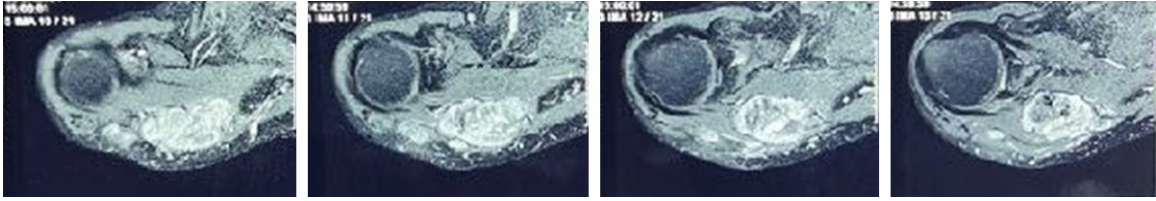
T2-weighted axial section MRI of shoulder showing large, focal well defined heterogeneously enhancing mass in the subcutaneous plane, abutting the spine of scapula, measuring approx. 5.6 × 8.5 × 2.7 cm in antero-posterior, transverse, and superoinferior dimensions.
